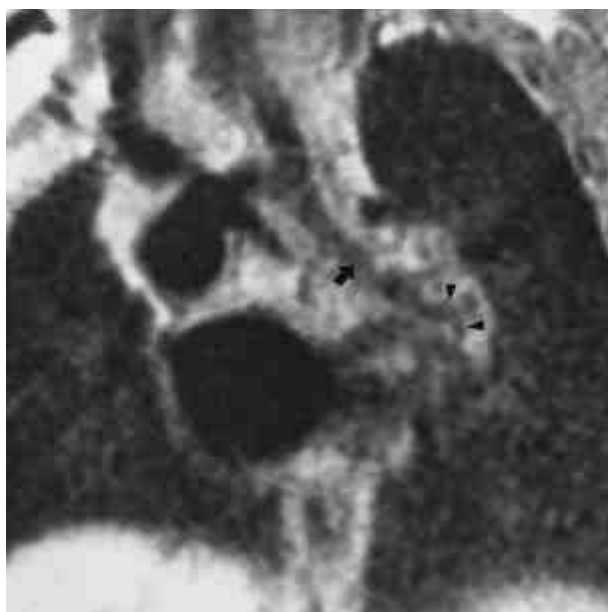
MR image in oblique coronal plane shows a signal void structure (arrow) in the left hilum. It was not possible to determine whether it represented the left main bronchus or the left pulmonary artery. A slightly tortuous structure in the more peripheral region (arrowheads) seemed to be a left lower lobar pulmonary artery.
